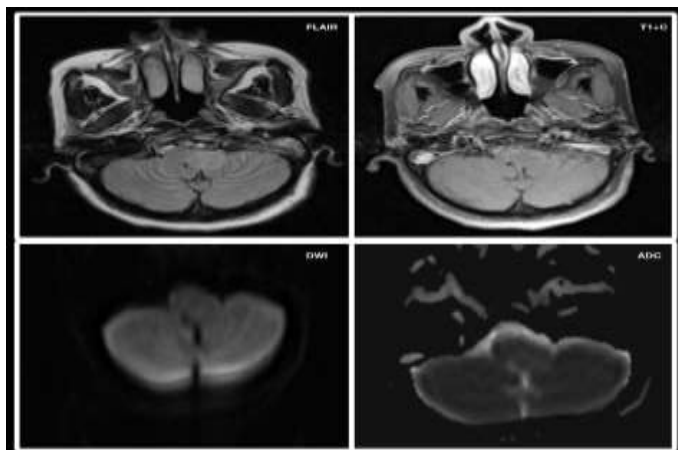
A 40 year old female with Neurofibromatosis 1: Rounded, well-defined, solid, non-enhancing lesion arising from the medulla seen extending into the cerebello-medullary cistern which appears hyperintense on FLAIR and shows no restricted diffusion suggestive of low grade glioma.
